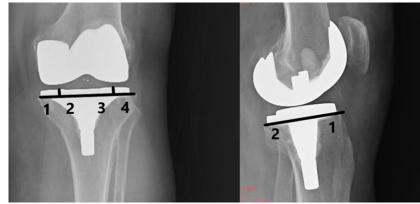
Anterior-posterior and lateral X-rays and zones according to Knee Society scoring system
